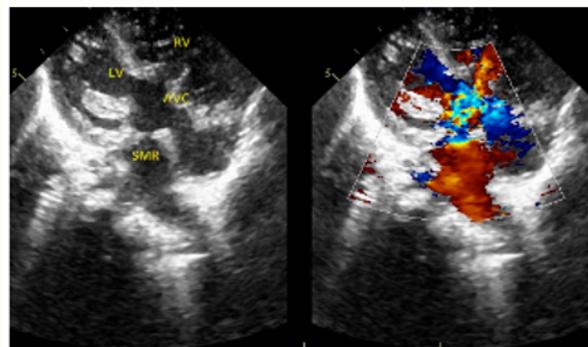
2-D color doppler apical TTE view in diastole showing the obstruction caused by the SMR.
